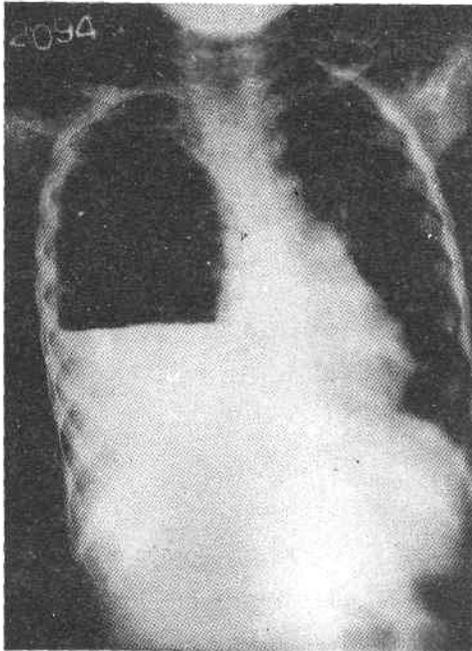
X-ray chest after repeated aspiration showing an air-fluid level.
